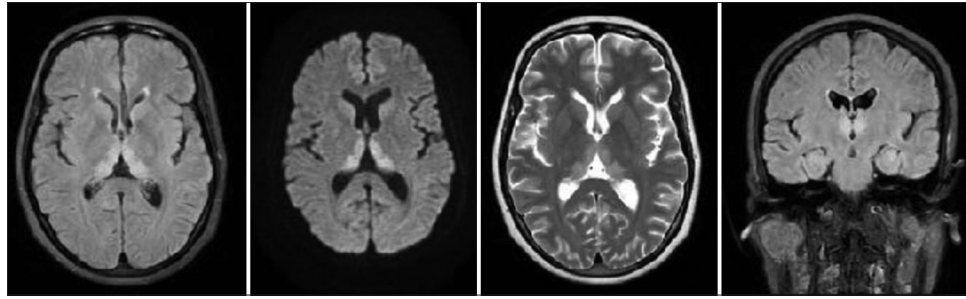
T2WI, FLAIR and DWI MR images showing hyperintensity in dorsomedial thalami and periaqueductal grey matter with diffusion restriction
